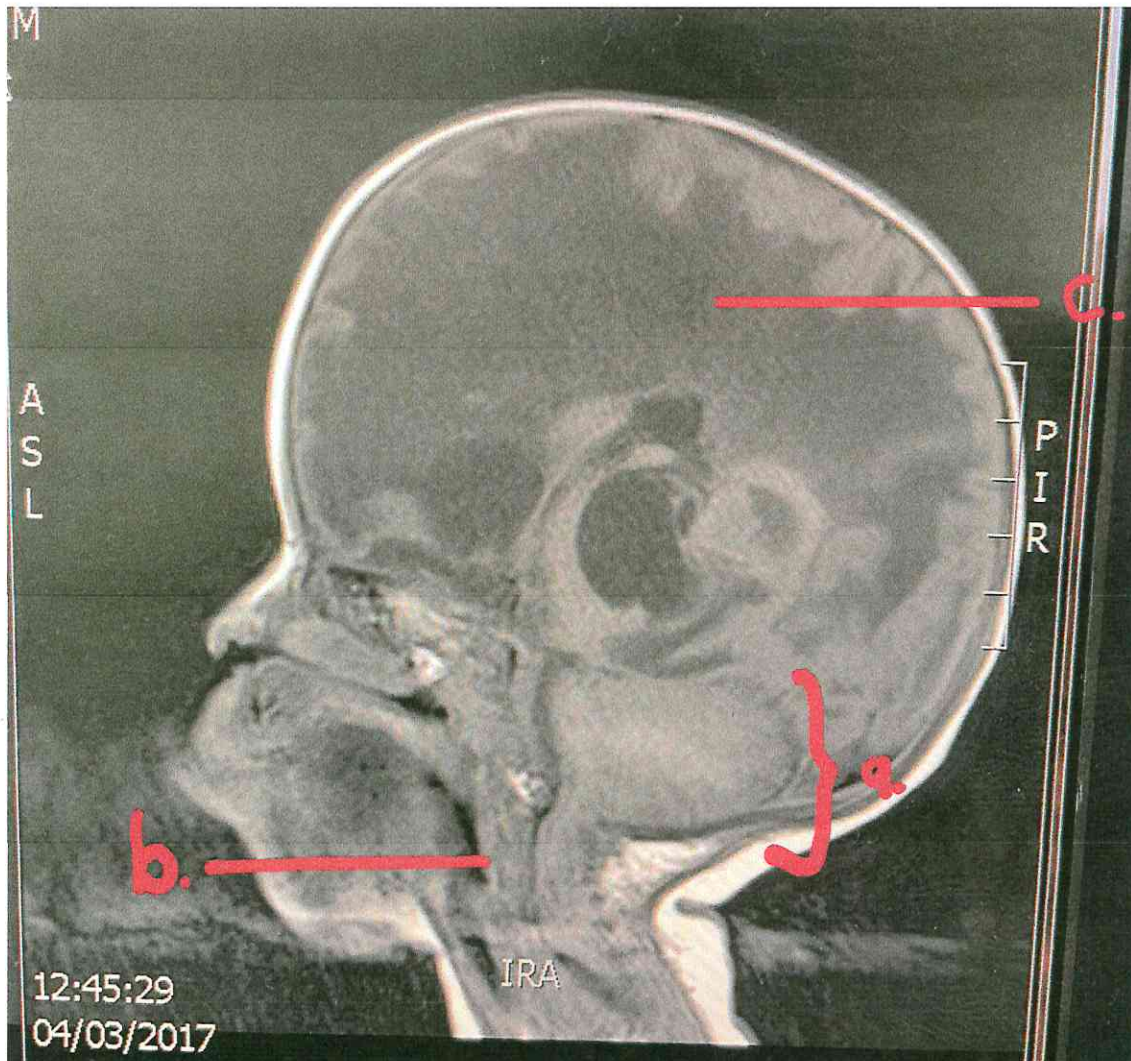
Sagittal T1-weighted image showing Chiari II malformation; the features include elongated brainstem that extends into the cervical spinal canal; (a)Smaller Posterior Fossa with downward herniation of the cerebellar tonsils into cervical spinal canal; (b)elongated brainstem extending into cervical spinal canal and just above that a small fourth ventricle; (c)There is also a thinned out, almost absent corpus callosum(24).
